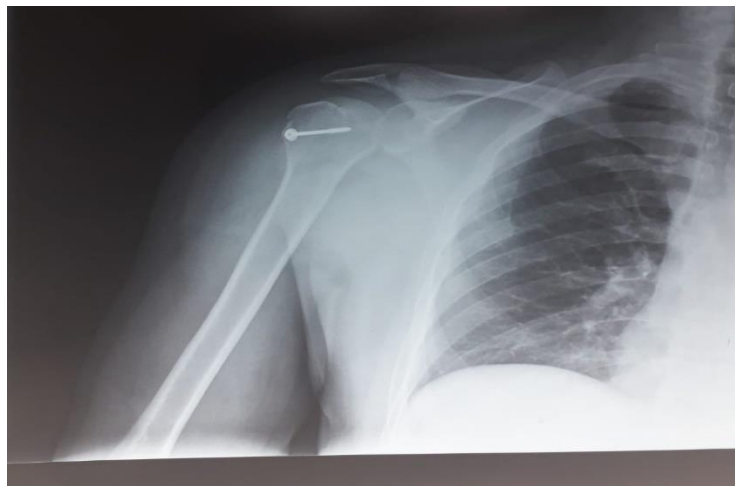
Front shoulder radiography showing screw osteosynthesis of the major tubercle.
